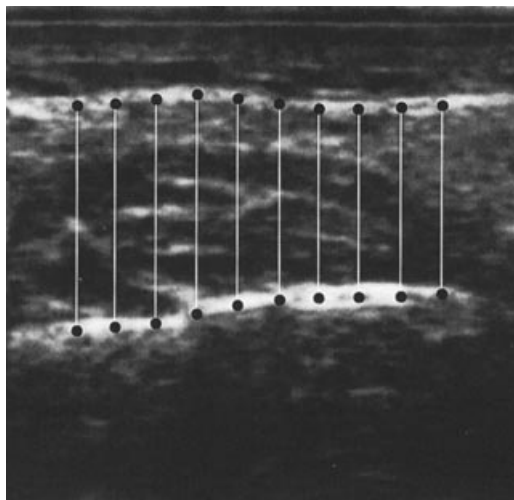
Transverse ultrasound image of the masseter muscle and measuring points. White wide shadows depict the fasciae of the masseter muscle. The shadow on the upper side is the outer fascia, and on lower side the inner fascia. The image of the masseter muscle lies between both the fasciae. The narrow white shadow above the outer fascia is skin echo. The dark area beneath the inner fascia is the lateral part of the ramus. Ten measuring points were set on both the inner and outer fasciae corresponding to the central area of the masseter muscle. The mean value at 10 point at intervals of 2 mm was regarded as the thickness of the masseter muscle.
